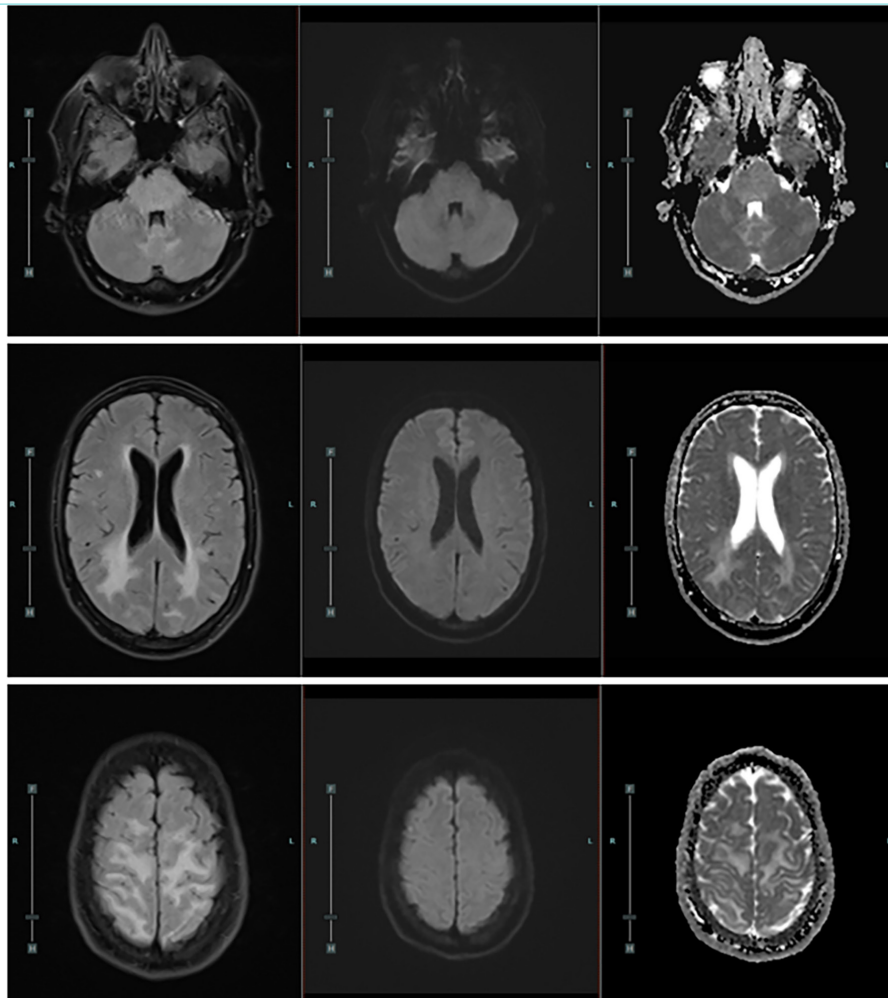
The axial FLAIR, diffusion-weighted imaging (DWI), and apparent diffusion coefficient (ADC) sequences demonstrate vasogenic edema prominently involving the pons, cerebellum, and bilateral temporo-parieto-occipital lobes. The lesions appear hyperintense on FLAIR and DWI images, while corresponding ADC maps show no significant diffusion restriction, supporting the vasogenic rather than cytotoxic nature of the edema.
